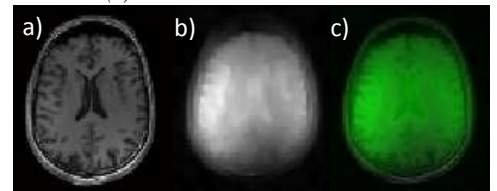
Comparison of ¹H MPRAGE (a), co-registered ¹⁷O MRI image with proton constrained with TA = 10 min (b and green in c) and fusion of both images (c).
